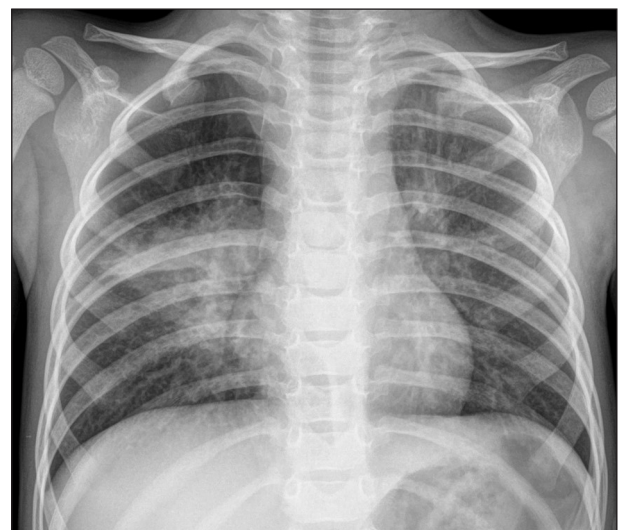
Frontal chest radiograph of one of the previous episodes, showing a consolidation on the mid third of the lung, adjacent to the right hilum, suggestive of pneumonia.
